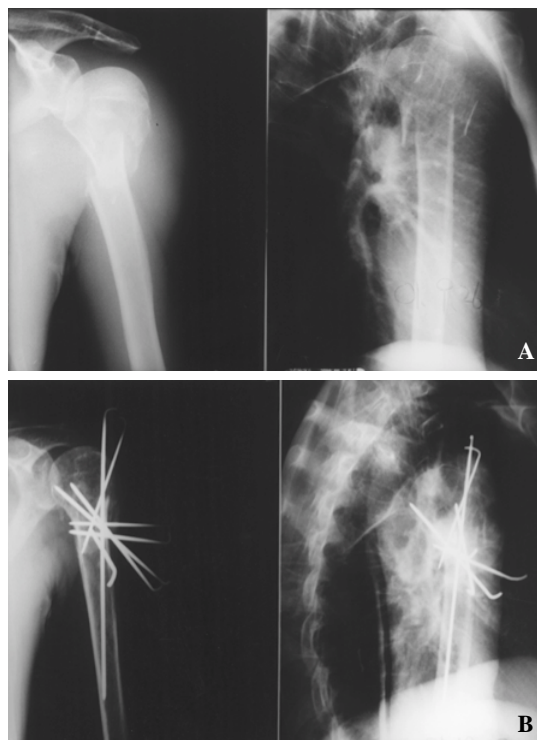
The preoperative radiograph shows comminuted proximal humerus fractures.
